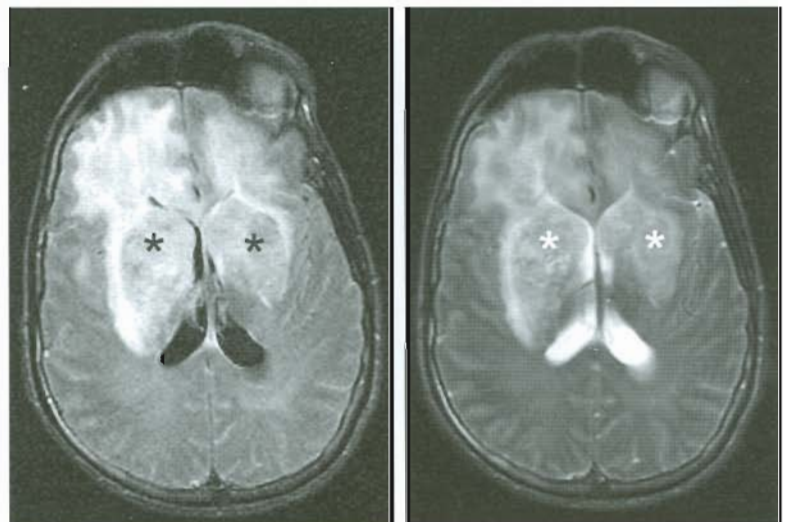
(left) and Figure 2 (right). Cerebral zygomycosis. FLAIR (figure 1) and T2-weighted (figure 2) images of the brain reveal diffusely abnormal signal intensity changes of the basal ganglia (*) as a consequence of fungal invasion. Inflammatory edema extends into the frontal lobes.
